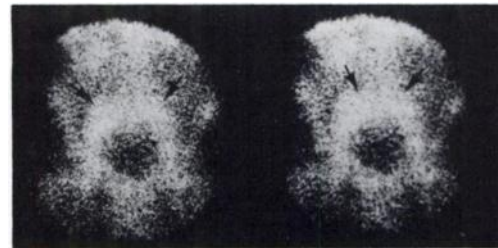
Early (6-hr, left) and delayed (48-hr, right) anterior ^{67}Ga scintigraphs in patient with loculated pelvic abscesses. There is virtually no difference between 6- and 48-hr scintigraphs.
